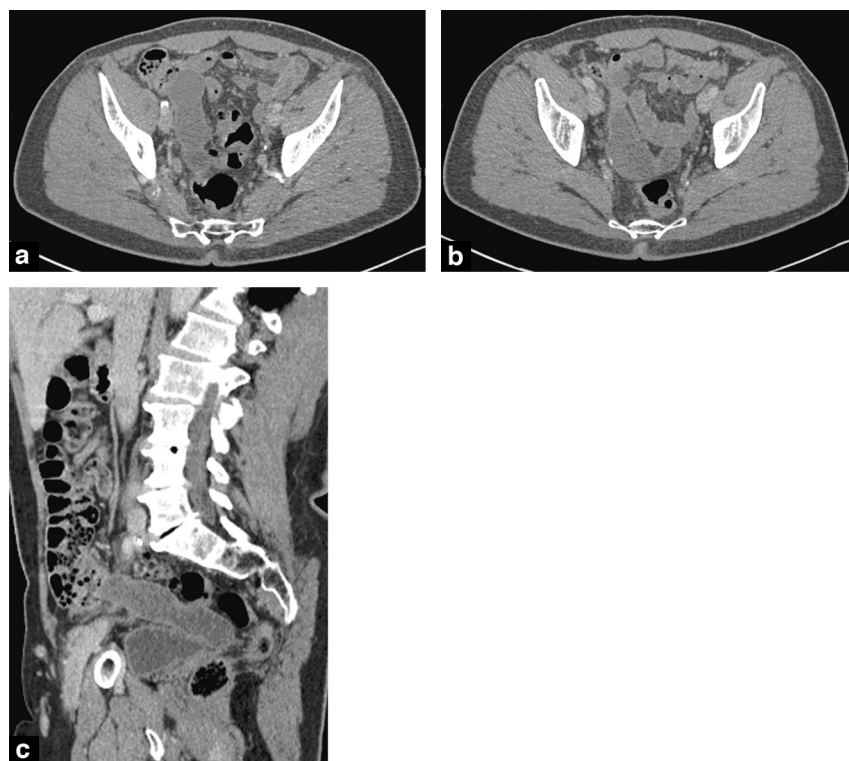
Abdominopelvic CT scan in the portal phase: a and b: axial slices; c: sagittal reconstruction.
